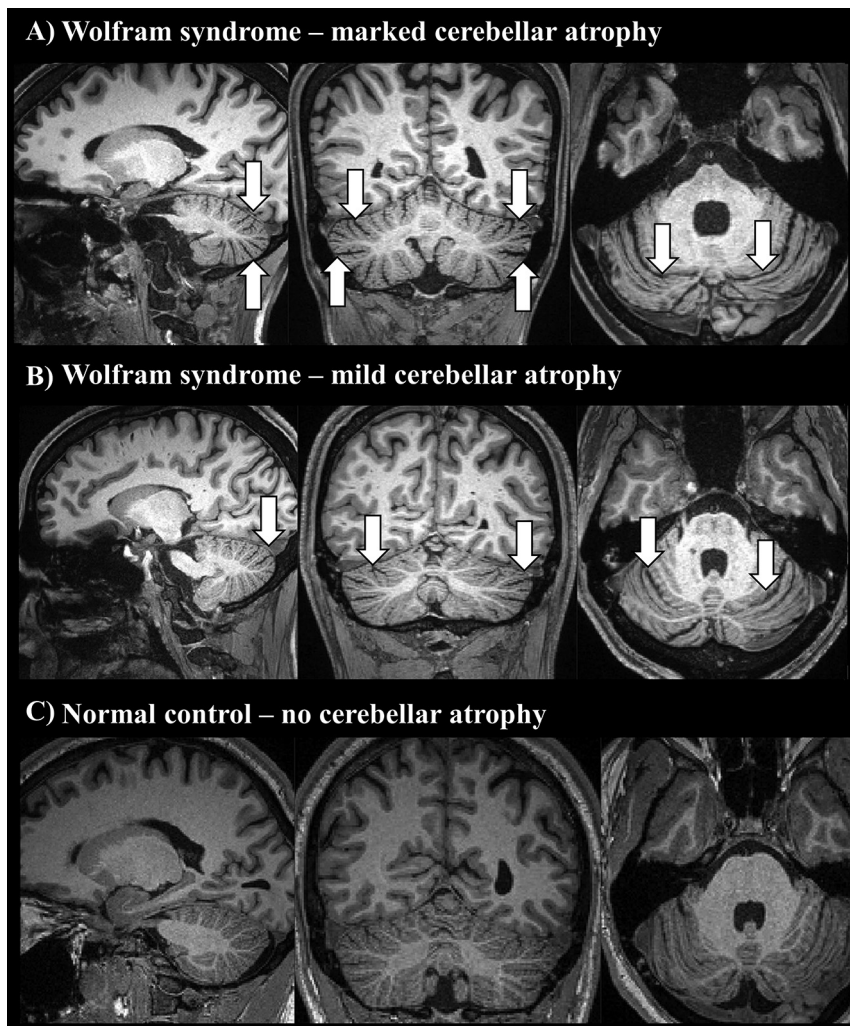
Marked (A) and mild (B) cerebellar atrophy in patients with Wolfram syndrome, as shown in sagittal, coronal, and axial T1-weighted MR images (white arrows), compared with a healthy control (C).
